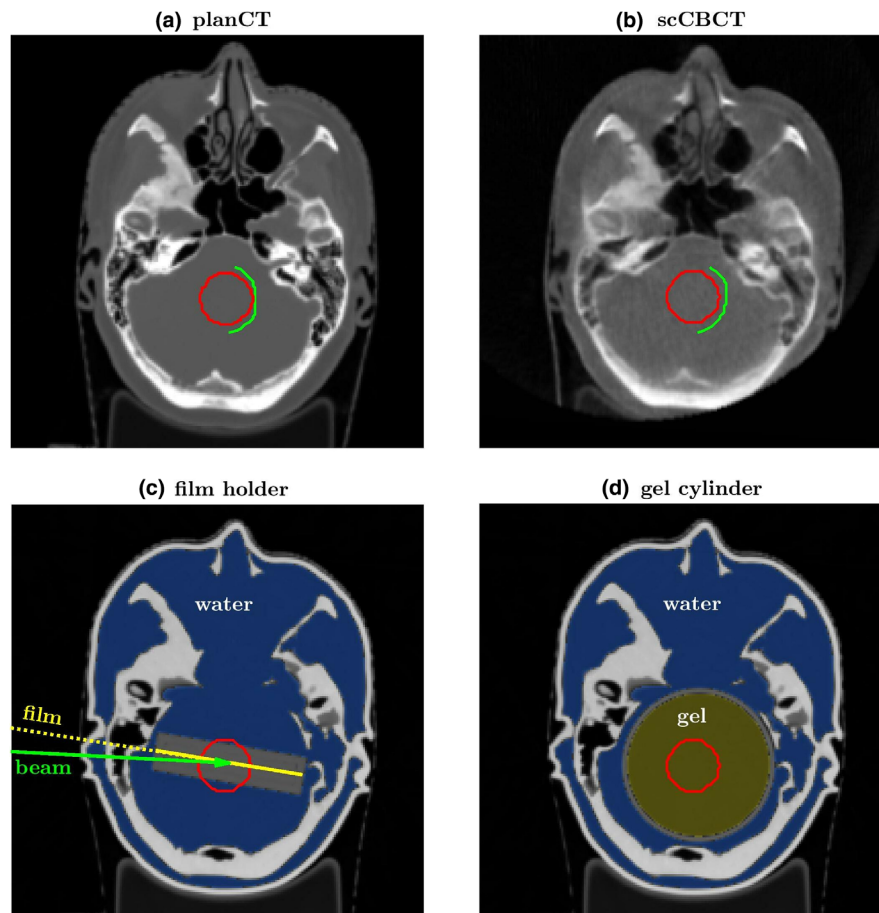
Exemplary axial slice of patient 1 of the planCT (a), the scCBCT (b), the 3D printed head with film holder (c) and with gel cylinder (d). The target volume is drawn in all subfigures with a red line. In subfigures a and b the distal 80% fall-off is indicated by a green line for  $NP_{\text{planCT}}$  and  $RP_{\text{scCBCT}}$  respectively. In subfigure c, the film plane and beam direction are highlighted showing the angular deviation of  $\sim 6^\circ$  in between. The water filling is shown in blue and the gel in the PMMA cylinder is marked in olive-green (d). [Color figure can be viewed at [wileyonlinelibrary.com](http://wileyonlinelibrary.com)]
